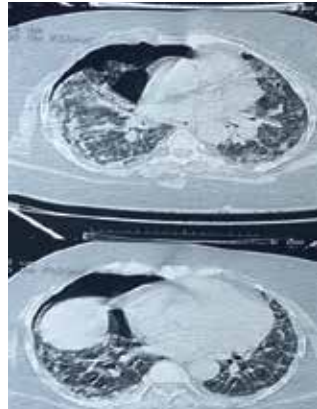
CT chest showing pneumothorax in right hemithorax with bilateral diffuse central and peripheral ground-glass, consolidative opacities
